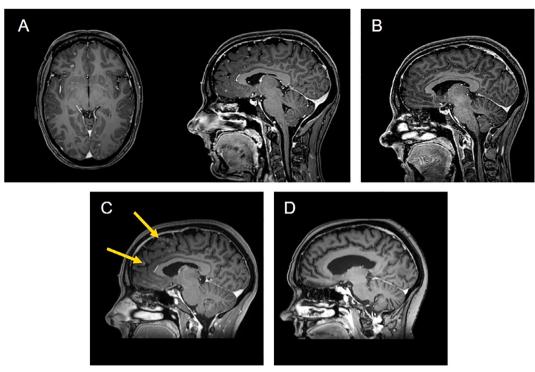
Brain magnetic resonance imaging scans. (A): August 2017: multiple disseminated brain metastases. (B): November 2017: complete resolution of the brain metastases. (C): May 2018: new secondary brain lesions (yellow arrow). (D): September 2018: complete resolution of the brain metastases.
